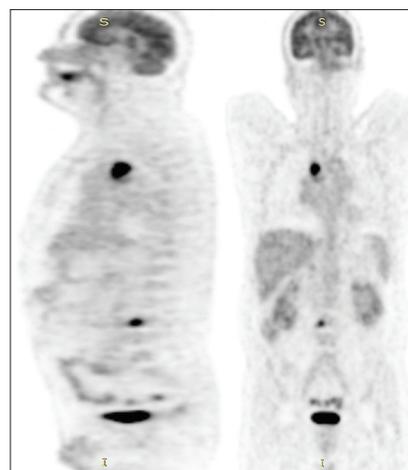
Positron emission tomography/computed tomography showing lymphadenopathy in the mediastinum and a lytic lesion was observed in the L3 vertebra
